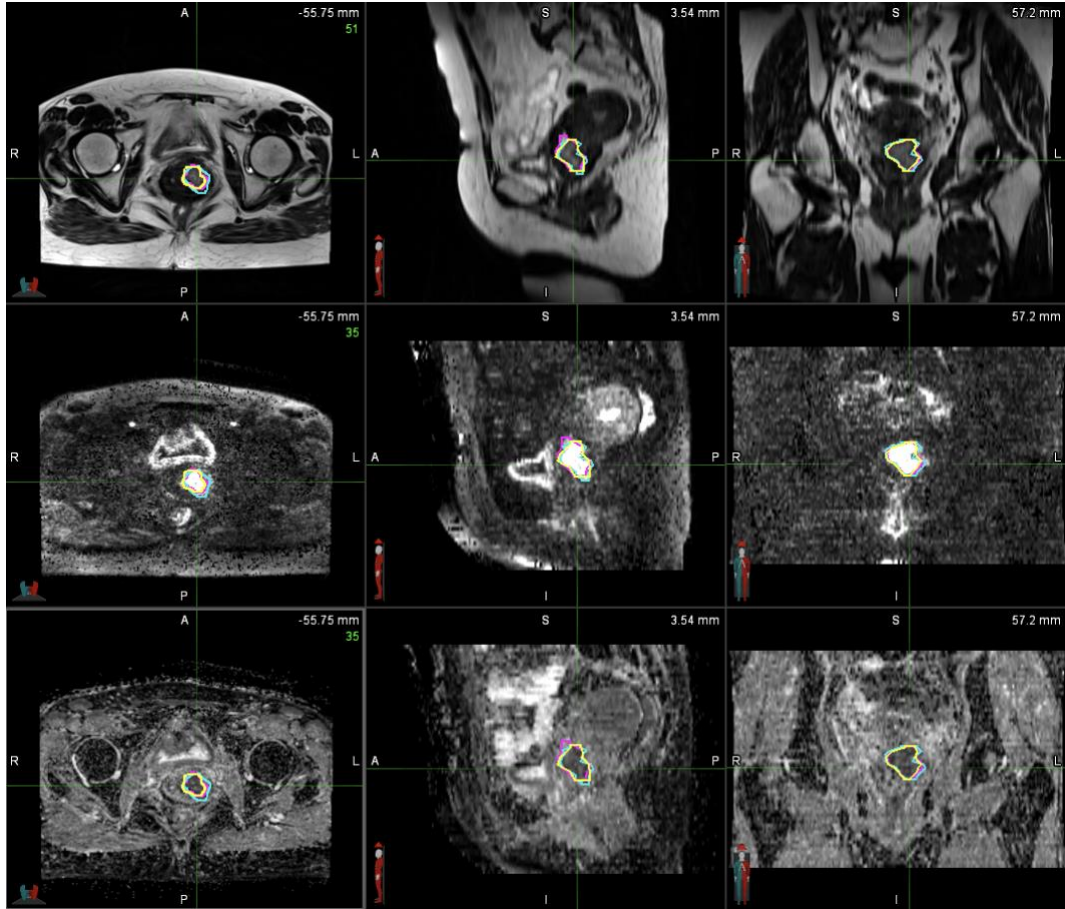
Example slice from Patient 3's a) pre-EBRT scan and b) pre-brachytherapy scan with the overlaid GTVs. The image rows from top to bottom for both scans are T2 MRI, DWI, and ADC. The GTVs contoured with the axial T2 MRI, with the axial T2 MRI/DWI fusion, and with the axial T2 MRI/ADC fusion are magenta, cyan, and yellow, respectively.
